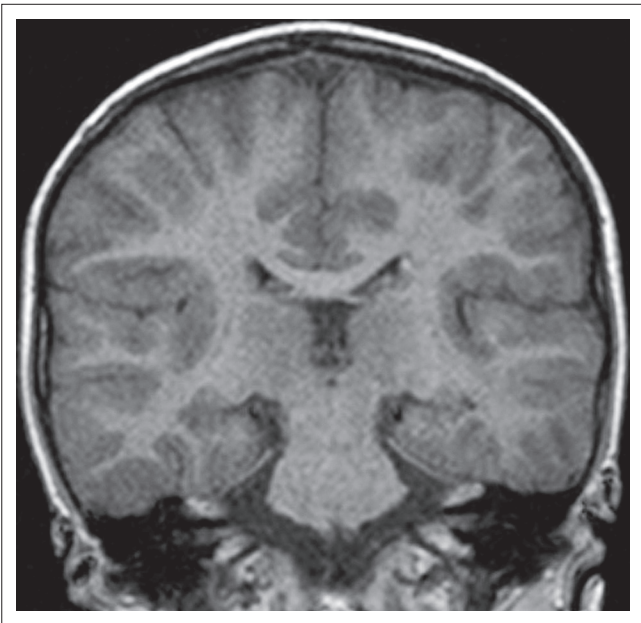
Coronal T1-weighted MR image.
